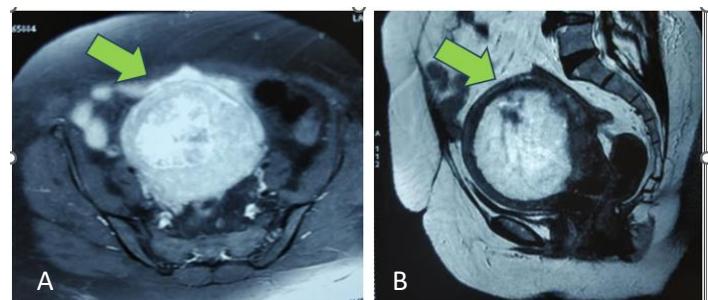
MRI of the whole abdomen (plain and contrast) 2a: Axial view showing a large ill-defined lesion in the endometrium with central degeneration likely representing a polypoidal lesion or endometrial malignancy. 2b: The sagittal view shows an ill-defined lesion in the endometrium with central degeneration and thinned myometrium.
